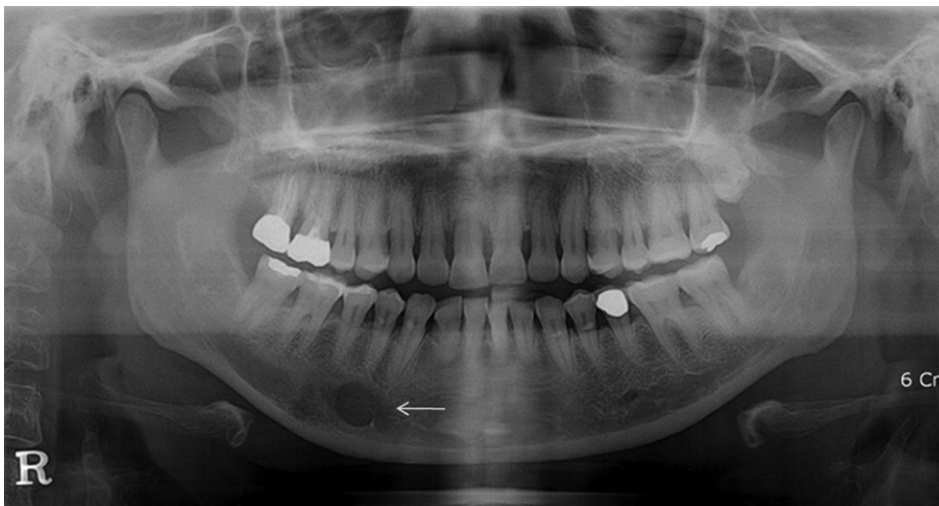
A panoramic radiograph shows an osteolytic lesion in the right premolar area (arrow).
